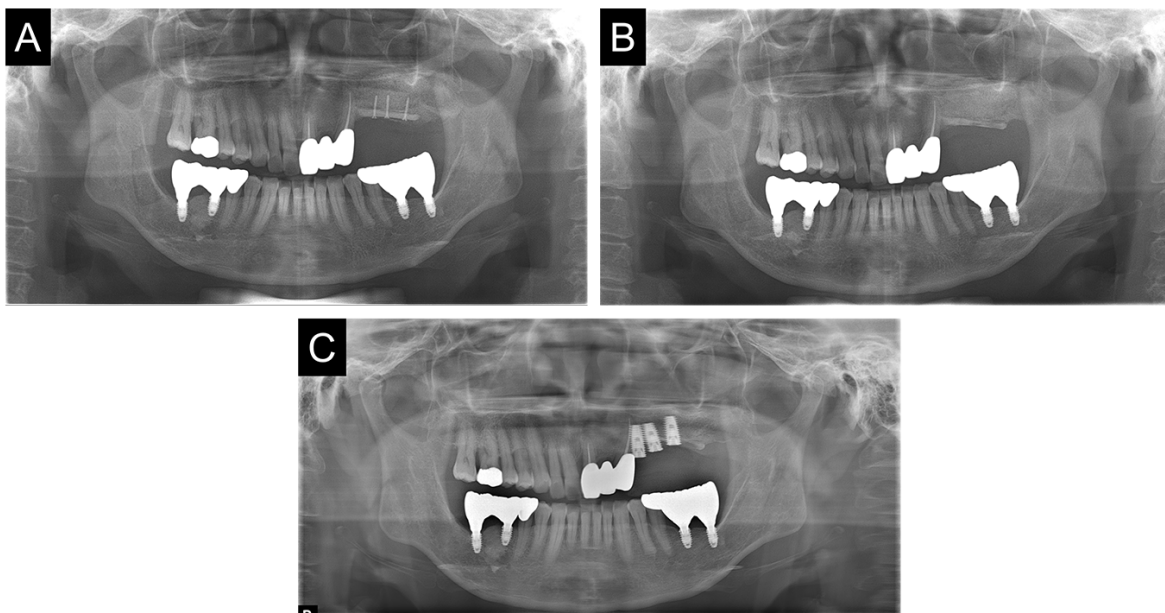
Panoramic radiographs after bone grafting. (A) Immediately after bone grafting; (B) After removal of the stabilization screws and curettage of the infected bone; (C) After implant installation.
